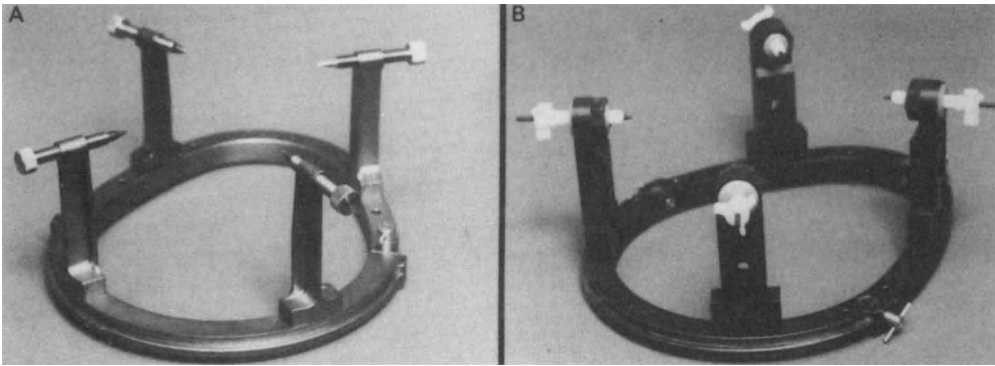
(A) Original head holder with metal vertical supports and skull fixation pins. (B) CT-compatible vertical supports with fixation sleeves and carbon-fiber pins secured by caps.
